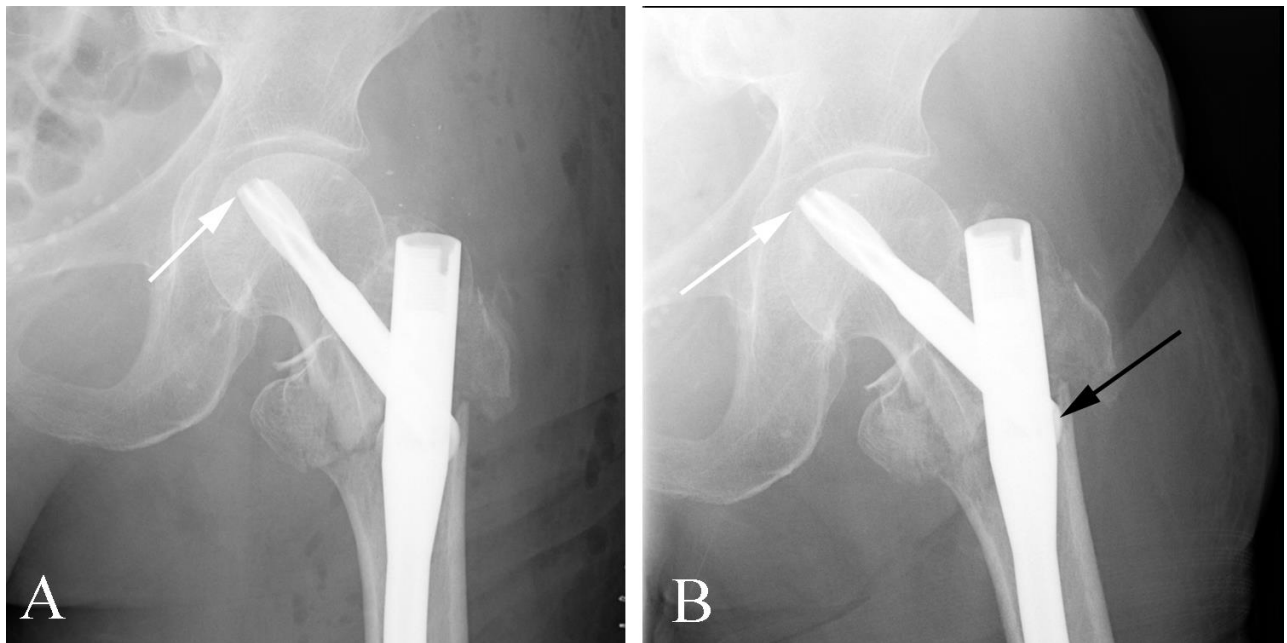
Complication of fixation device in an 82 year old woman s/p ORIF. A. AP plain film of the hip demonstrates the fixation device with an intramedullary rod and interlocking blade-plate with the tip of the blade-plate device projecting inside the femoral head (arrow). B. AP plain film shows migration of the helical blade plate through the femoral head cortex. Such migration is generally prevented in these devices because the device can “back out” of the medullary rod. In this case, the position of the device prevented “backing out” because the sliding, interlocking helical blade plate was covered by the margin of the femoral shaft (black arrow).
